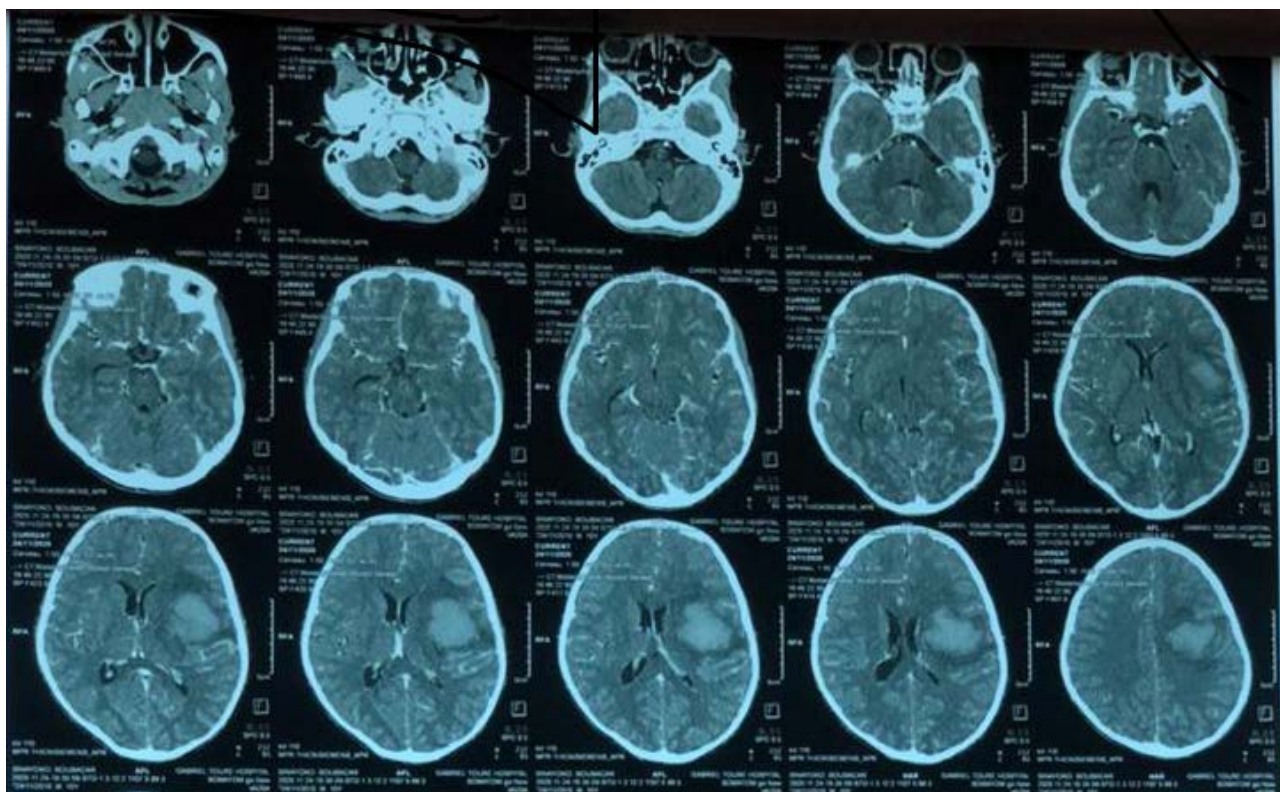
CT appearance in favor of hemorrhagic stroke with ventricular flooding.
